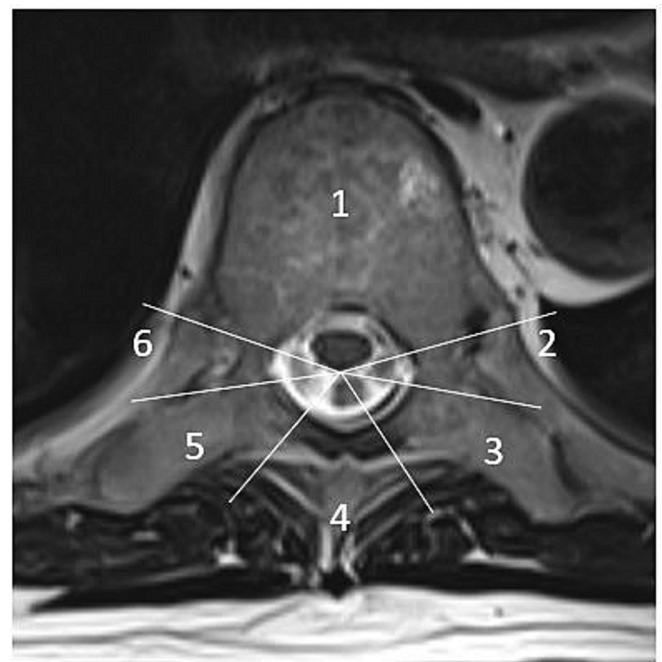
Axial MRI of a vertebrae with the ISRC sectors (1) vertebral body, (2) left pedicle, (3) left transverse process and lamina, (4) spinous process, (5) right transverse process and lamina, (6) right pedicle.
